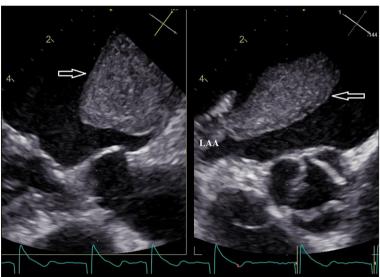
Transesophageal echocardiography, mid-esophageal view. Intra-atrial thrombus (arrow).
